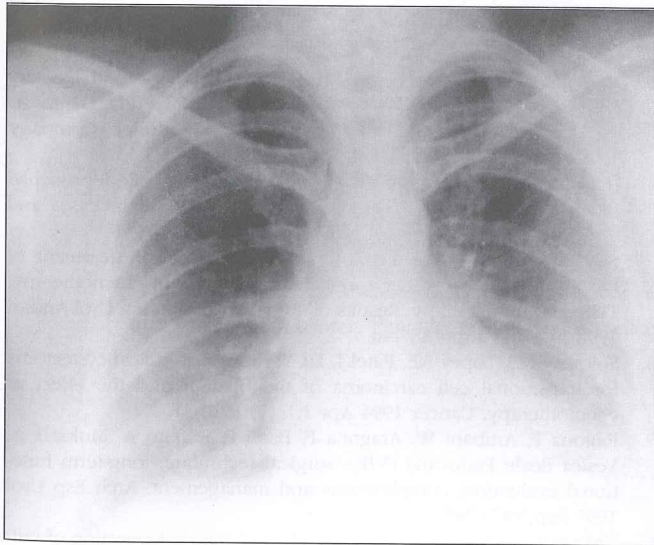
Chest X-ray (1997)
